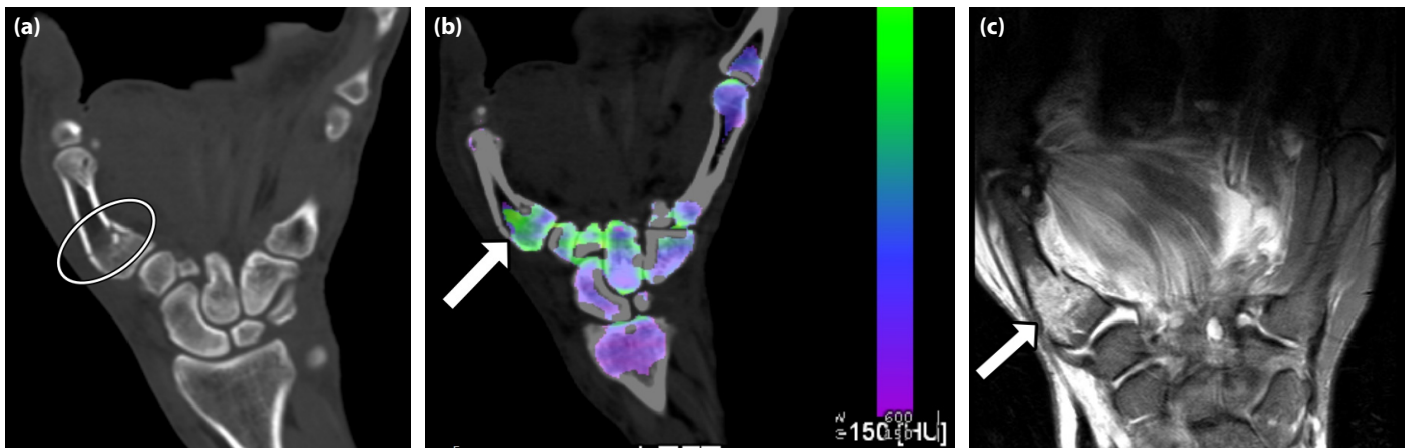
Images in a 57-year-old man with clinical suspicion of a wrist fracture one day after trauma: (a) Coronal reformation of a conventional CT reconstruction, (b) Dual-energy CT color-coded virtual noncalcium, and (c) Coronal fat-saturated T2-weighted MRI scan image of the right wrist. Bone marrow edema is visible both in the MRI and dual-energy CT (arrow in b and (c)) at the first metacarpal base. Extraarticular fracture lines are evident in the conventional CT image (ellipse in a).
